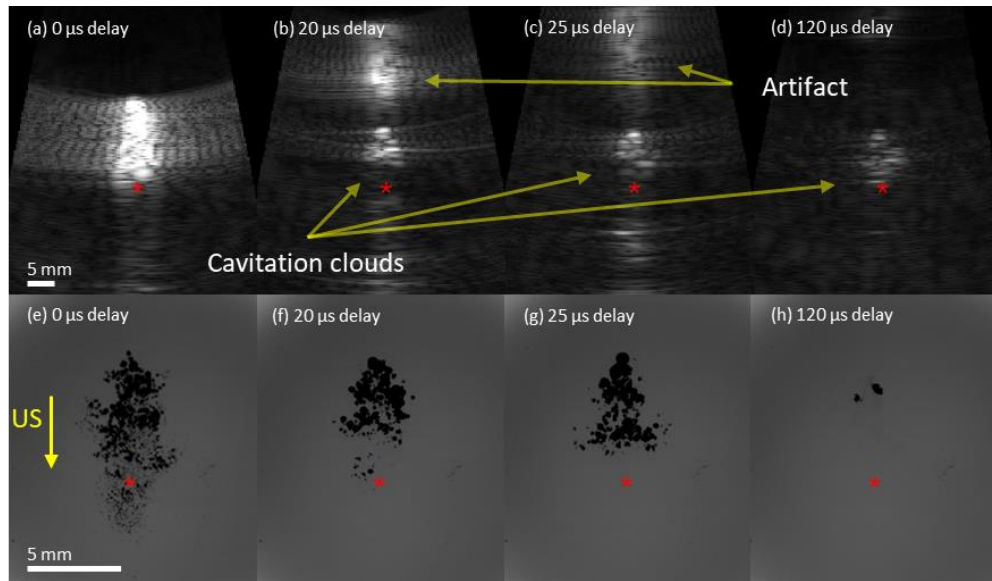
Plane wave B-mode and high-speed photography acquired images at different B-mode transmission delays after transducer transmission at acoustic power 783 W. At a particular delay, both images are of the same cavitation cloud. The arrow beside ‘US’ denotes the direction of ultrasound beam. Position of the geometric focus is indicated by a red asterisk.
